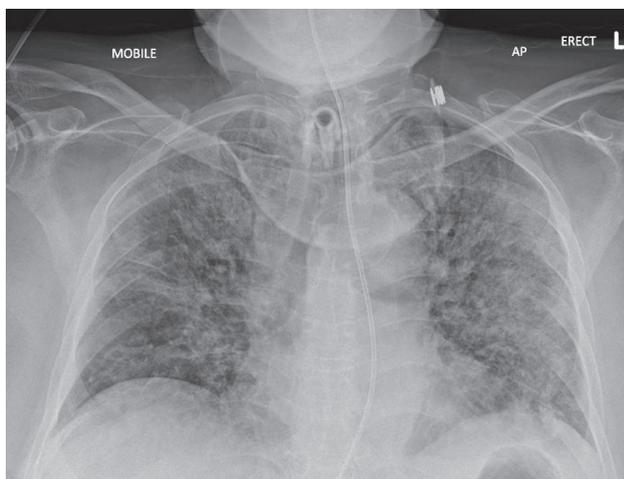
Patient's anteroposterior radiograph demonstrating typical features of COVID-19 disease, with extensive, bilateral ground glass opacification and consolidation extending to the periphery of the lungs. As is typical, there is no overt pleural fluid or lymph node enlargement. A nasogastric tube and a tracheostomy with a Buchanan Protector are also present.
